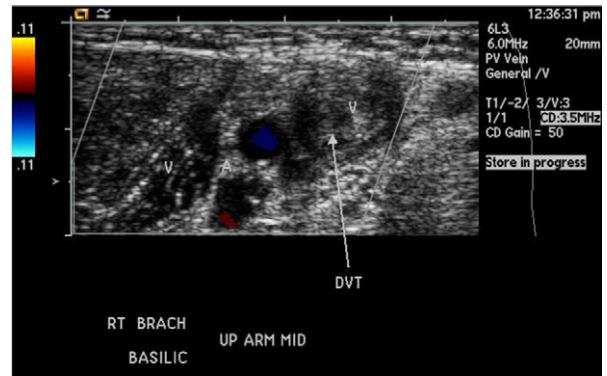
Color Doppler duplex ultrasonography demonstrates right brachial and basilic vein deep venous thrombosis (DVT).
